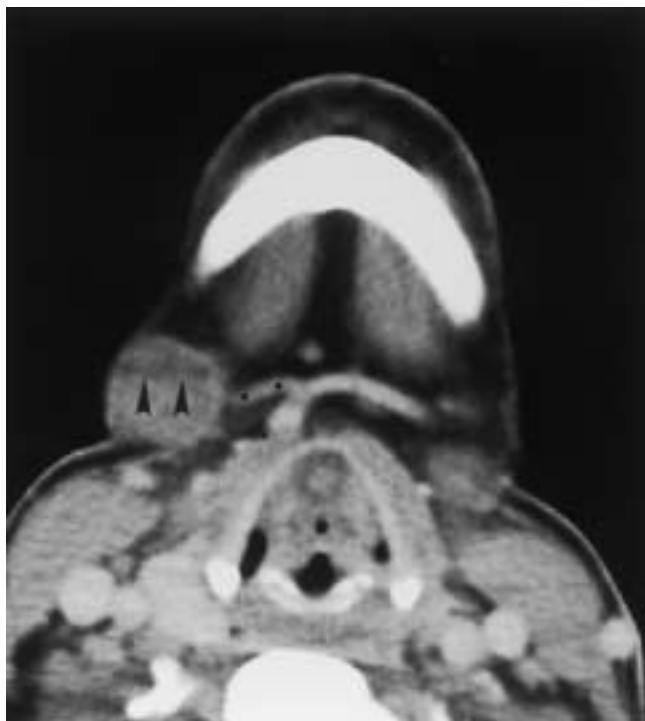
Lingual artery aneurysm. Axial contrast-enhanced CT scan in a 23-year-old female with a right submandibular region mass clinically demonstrates a well-circumscribed lesion on the right. A fluid level is visible within the lesion (*arrowheads*), and a branch of the right lingual artery can be seen entering this lesion (*black dots*).
